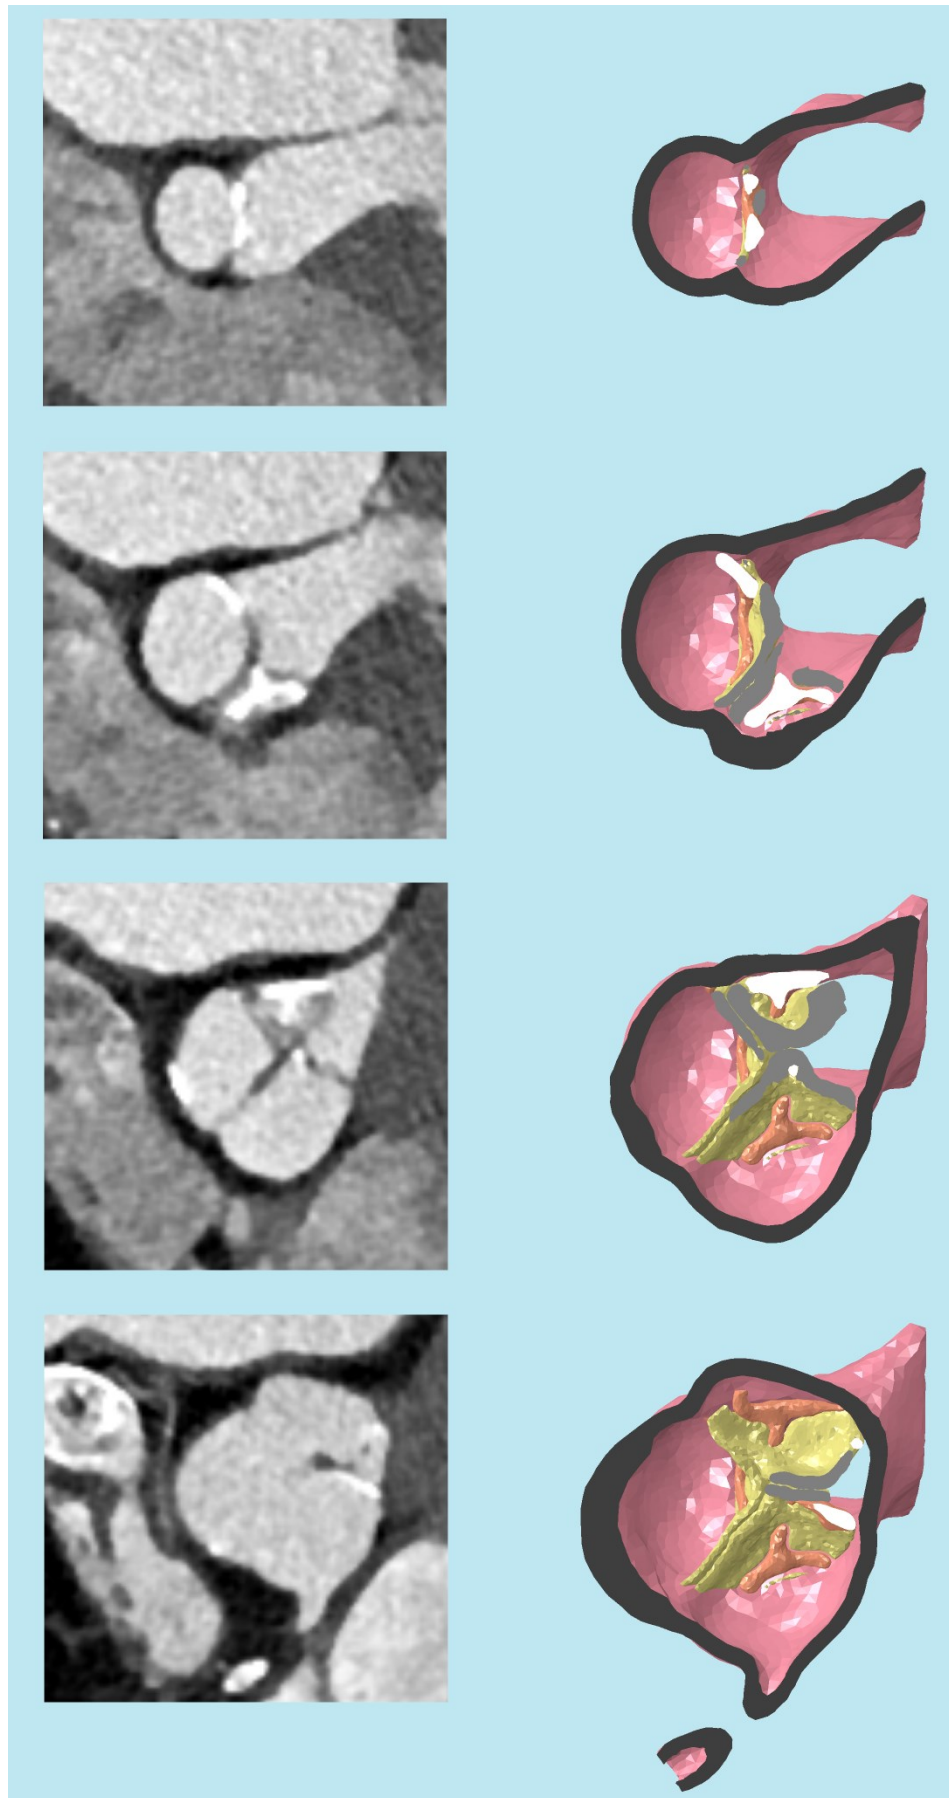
A comparison between medical CT scan images and the respective section of the aortic root model. The aortic root wall is seen in dark grey, the leaflets are light grey and the plaques are white.
